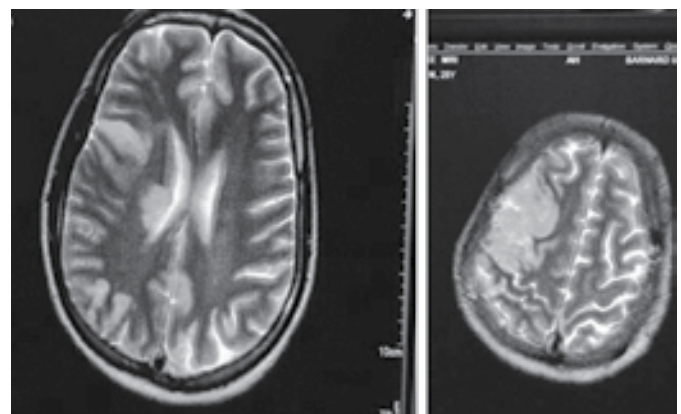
MRI –brain taken next day, demonstrating right parietal and right gangliocapsular infarct
